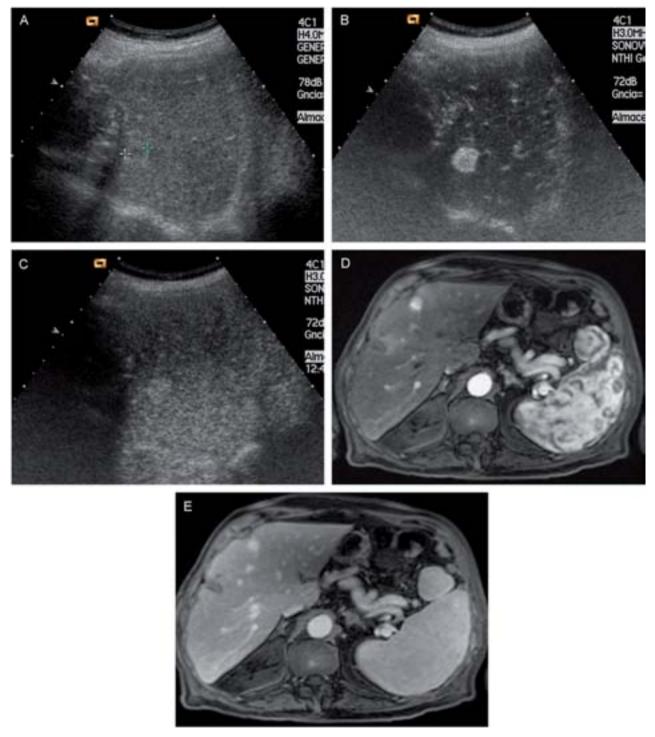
A lesion detected in the semi-annual screening ultrasound of a cirrhotic patient. A differential diagnosis should be done between hemangioma or HCC. A) In the baseline ultrasound, an echogenic, 17 mm nodular image with a more hypoechoic center is observed (cursors). B) CEUS: in the arterial phase, the lesion presents clear and complete contrast uptake. C) CEUS: in the delayed venous phase, the lesion remains hyperechogenic, which is uncharacteristic of HCC and supports the diagnosis of a benign lesion. D) Complete nodular uptake of the lesion in the arterial phase of the MRI. E) In the delayed venous phase, persistent uptake is identified. The lesion was characterized as a hemangioma.
